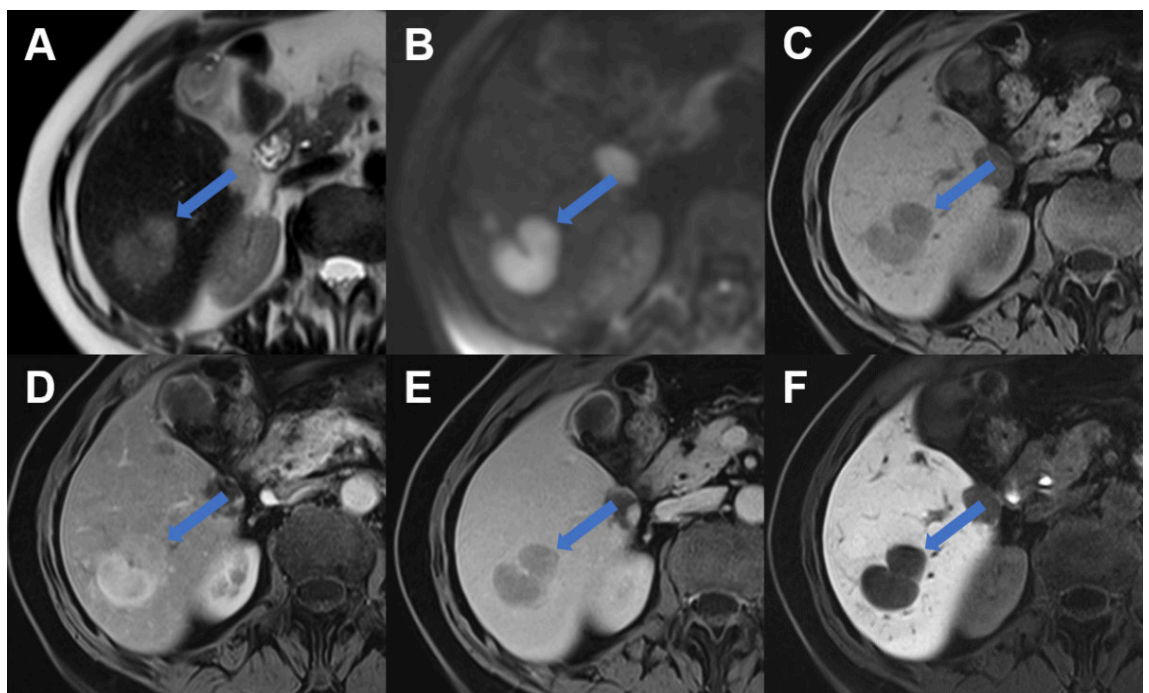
Liver metastasis on MRI. Liver metastasis in segment VI laterally (arrow) with A slight hyperintense signal on T2w image, B restricted diffusion with high signal on b800 diffusion weighted image, C hypointense signal on T1w image, D arterial enhancement, E portal venous wash-out and F hypointense signal during the hepatobiliary phase due to lack of contrast metabolism.
